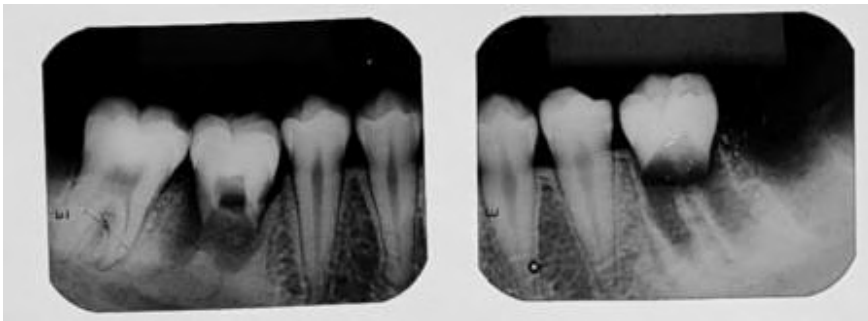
Periapical radiographs 21 days after auto transplantation.
